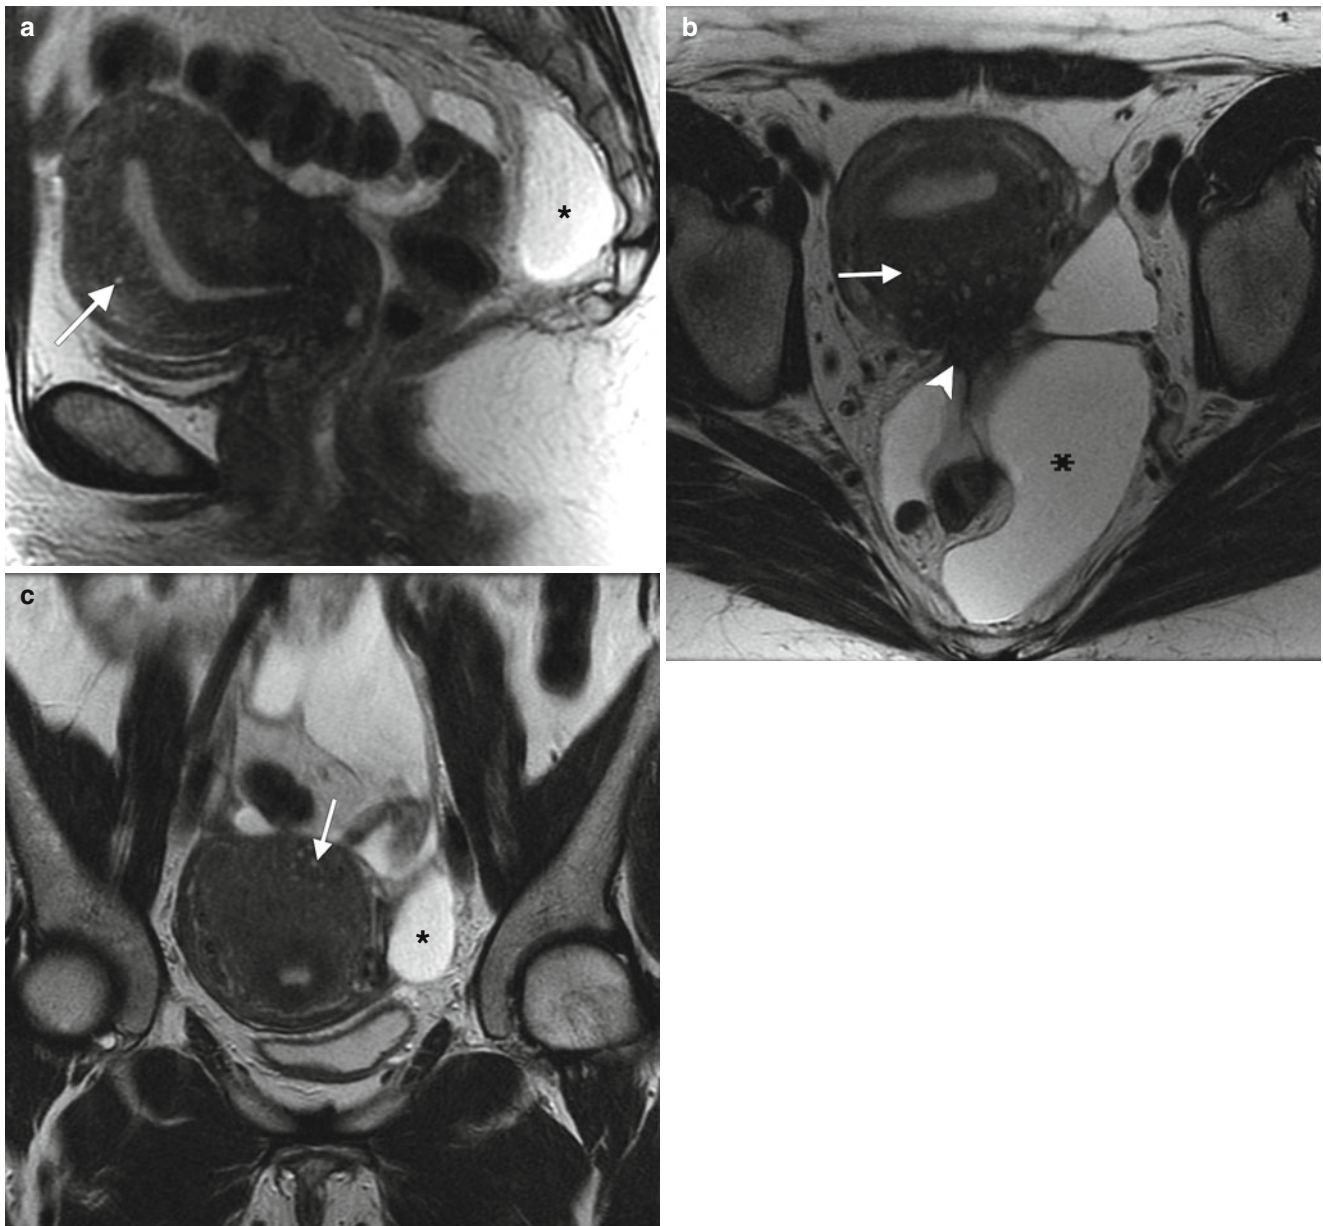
42-year-old woman with a history of appendectomy and myomectomy for dysfunctional uterine bleeding. Sagittal (a), axial (b), and coronal (c) T2-weighted MR images demonstrate thickening of the junctional zone with small T2-hyperintense spaces (arrows) consistent
